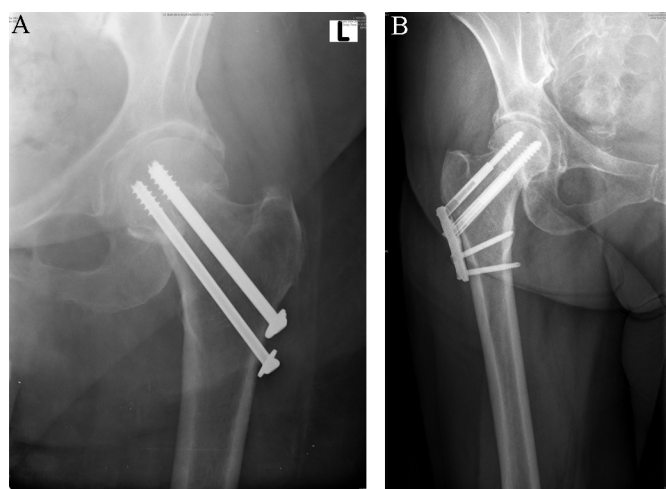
(a) This image is a standard X-ray of a patient status post fixation via CCS for ICHF. (b) This image is a standard X-ray of a patient status post fixation via Targon FN for ICHF.
